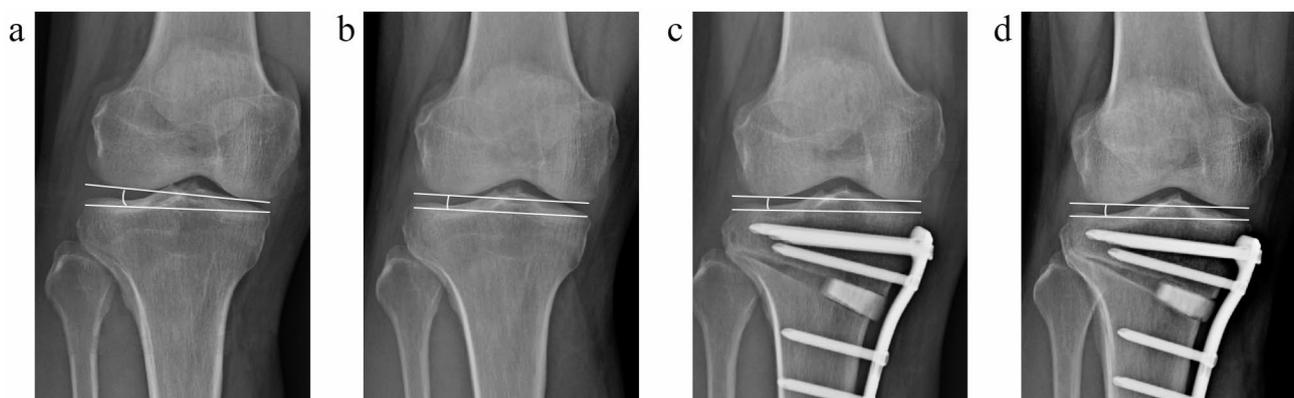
Radiographic analysis of joint line convergence angle (JLCA). a preoperative JLCA in the standing position. b preoperative JLCA in the supine position. c postoperative JLCA in the standing position. d postoperative JLCA in the supine position
